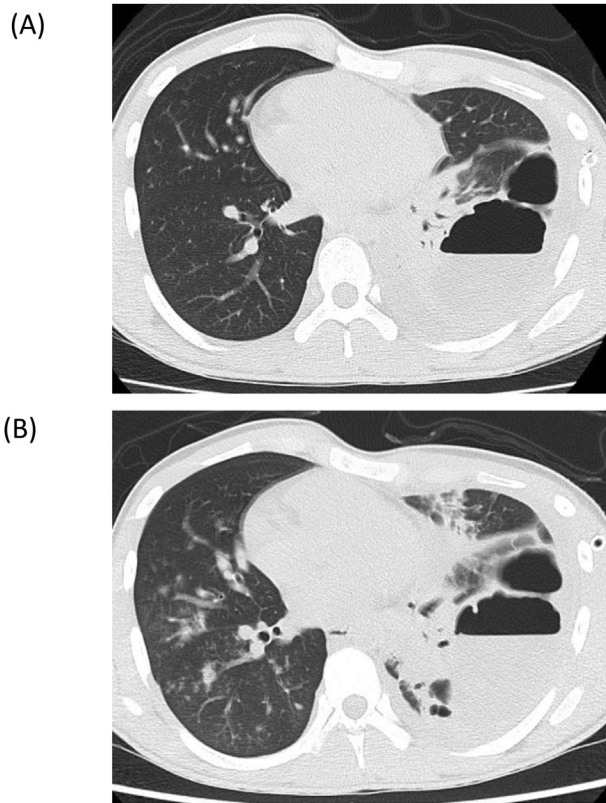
Chest computed tomography (CT) images. (A) Chest CT scan acquired after the insertion of a drainage tube shows mass-containing cavity lesions surrounded by consolidations. (B) Chest CT scan acquired 15 days after admission shows multiple bronchiolar nodules in the right lung field.
